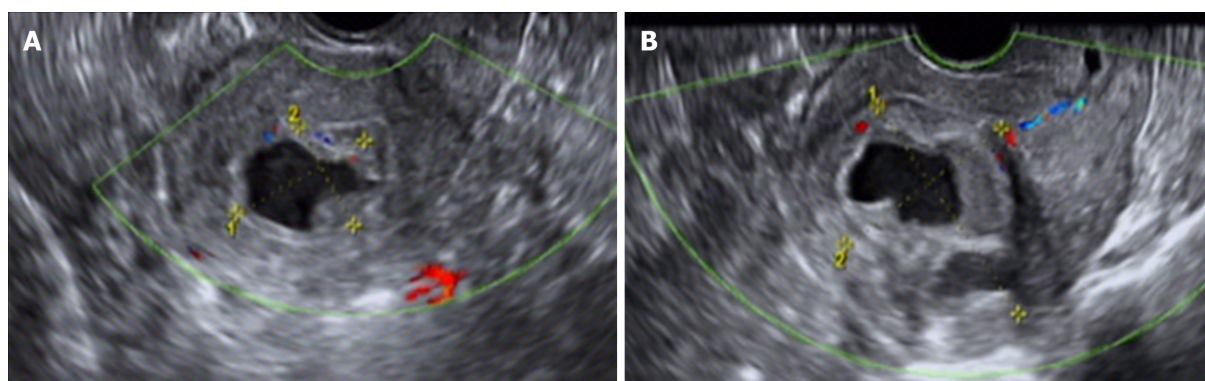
Ultrasonic images of intrauterine cystic adenomyosis. Regularly shaped lesions with a high-level echo and strong echo halo around the lesions can be seen in the uterine cavity, and cysts can be seen in the polyp. Color Doppler can display the typical single blood flow signal supplying the endometrial polyps. A: Case 1; B: Case 2.
